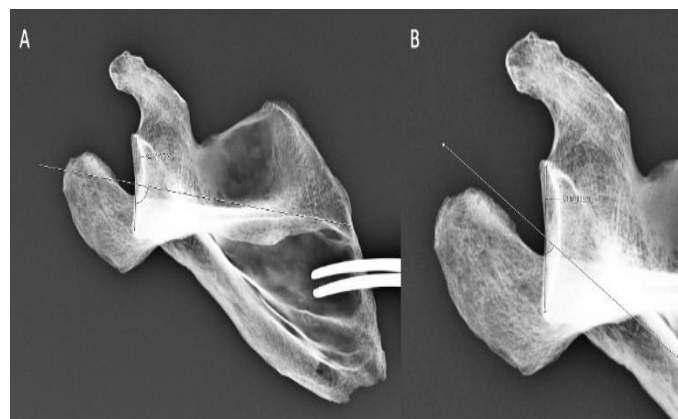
Glenoid retroversion measurements with scapula in 20 degree of posterior tilt. Kelly clamp and scapula placed against precut 20-degree block of wood to obtain radiograph in rotation. A) And B) demonstrate the differences between Technique 1 and Technique 2, respectively, precisely as outlined in Figure I
